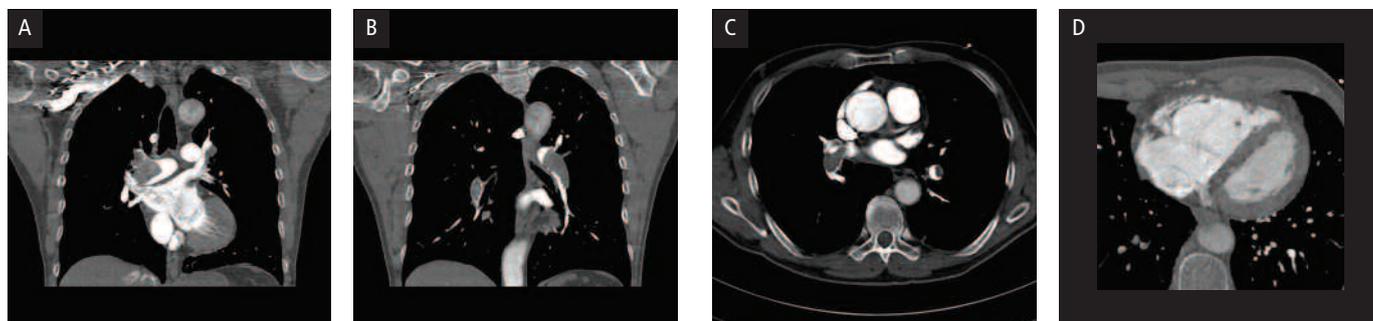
Computed tomography scans showing bilateral main pulmonary artery pulmonary emboli with extension into the left lower lobe segmental branch (panels A, B, and C). There was also right ventricular enlargement with contrast reflux into the IVC and hepatic arteries, suggesting right ventricular dysfunction (panel D).
